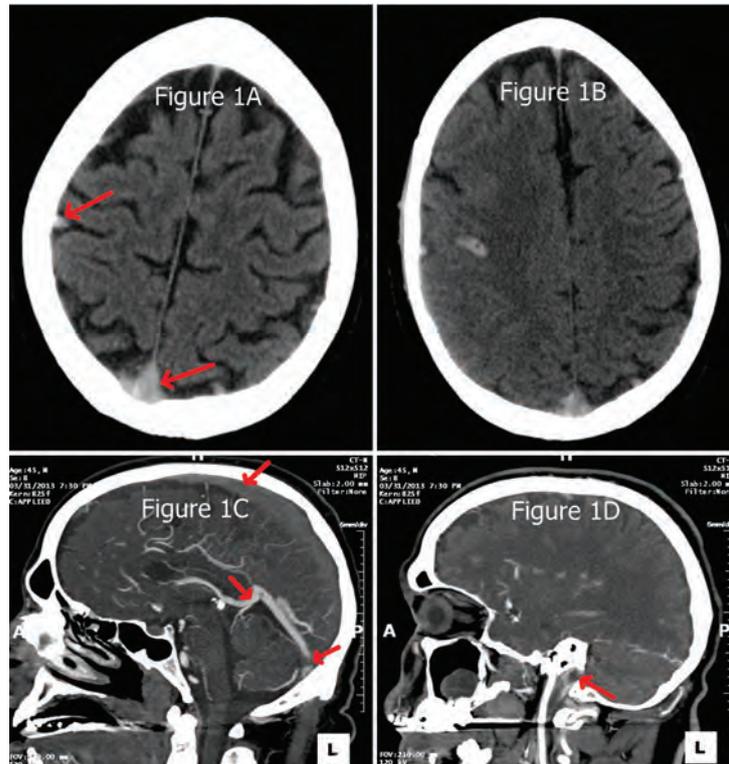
Non contrast CT - Vein of Trolard (VOT) (left arrow) & Delta ( $\Delta$ ) Signs (bottom middle arrow); Figure 1B – Non Contrast CT - VOT and  $\Delta$  signs, as well as right subcortical parenchymal hemorrhage from venous hypertension; Figure 1C – Sagittal CT venogram – Sagittal sinus thrombosis (top arrow), patent vein of Galen (middle arrow) and thrombus at the confluence of the transverse and straight Sinuses (bottom right arrow); Figure 1D – Sagittal CT venogram – Thrombus at the top of the jugular vein at the jugular foramen (arrow).
